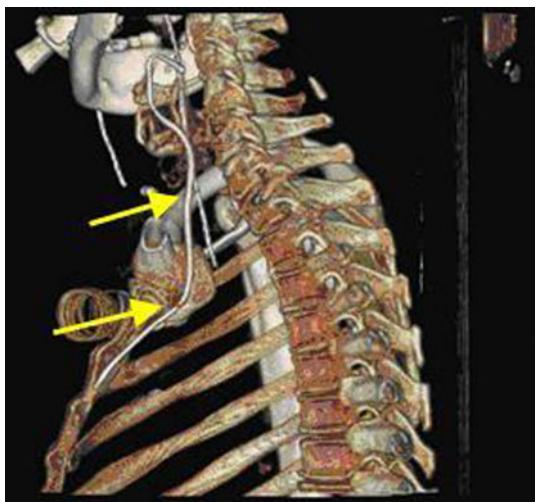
The thoracic CT scan with 3D reconstruction shows the catheter (arrows) behind the sternum in the left internal mammary vein
